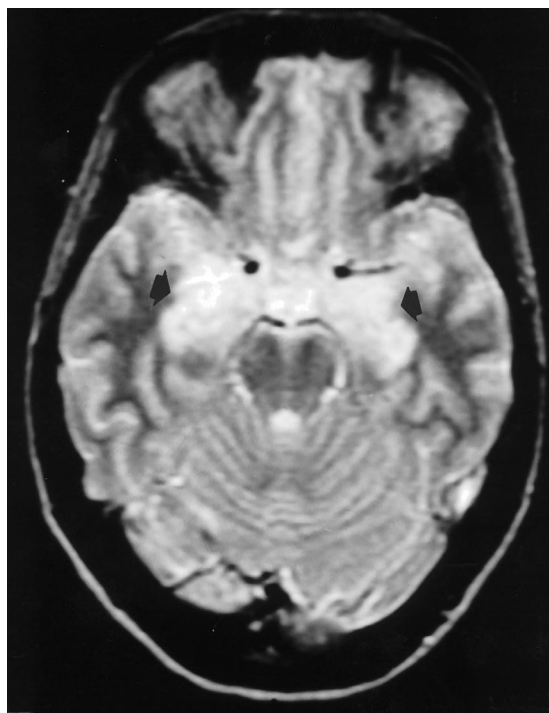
Axial T2-weighted MRI brain scan through the temporal lobes shows bilateral areas of increased signal intensity involving the mesial temporal lobes and hippocampi (arrows).
